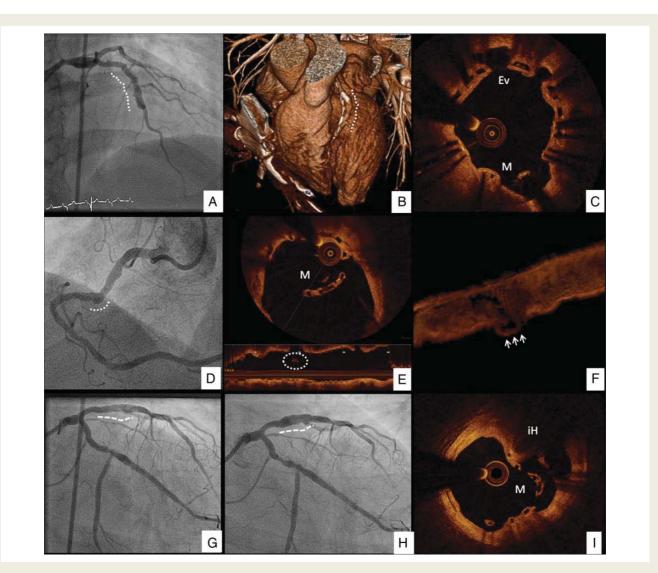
(A–C) A case of coronary artery aneurysm at the level of the proximal left anterior descending in a 44-year-old woman who presented with ST-elevation myocardial infarction and received a 3 × 18 mm bioresorbable vascular scaffolds in the proximal left anterior descending. Of note, the aneurysm was not present 1-month after implantation, and a similar aneurysmatic reaction was present in another bioresorbable vascular scaffolds implanted in the same patient in the right coronary artery. (*B*) Computed tomography scan of the proximal left anterior descending revealing an ~6 mm aneurysm 18 months after implantation. (*C*) Evidence of evaginations (Ev) and malapposition (M) in the same patient. This case is described in detail in Ref. ³¹ (*D*–*F*) late acquired small saccular aneurysm in the mid right coronary artery in a 75-year-old patient who received a 3 × 18 mm in the setting of unstable angina. 12-months optical coherence tomography at this level demonstrated (*E*) collapse of the struts, which were otherwise well apposed in the proximal and distal segments (longitudinal view, white circle). 3D reconstruction confirmed the aneurysm and the collapse of the struts (arrows and dashed circle). (*G*–*I*) the last case of aneurysm was observed in a 69-year-old man who received a 3 × 18 mm bioresorbable vascular scaffolds in the proximal left anterior descending. It is possible that a trauma caused by high-pressure post-dilation with a 3.5 mm balloon might have triggered the aneurysmatic process in this case. (*G*) Immediate result showing overexpansion of the bioresorbable vascular scaffolds (dashed line); (*H*) 12-month angiography showing aneurysmatic evolution of the lesion. (*I*) Optical coherence tomography demonstrating a fibrolipidic plaque protrusion (1 o'clock) which prevented the deployment of the scaffold and required high-pressure dilation, ultimately leading to vascular injury and malapposition. ih, intramural hemoatoma.
